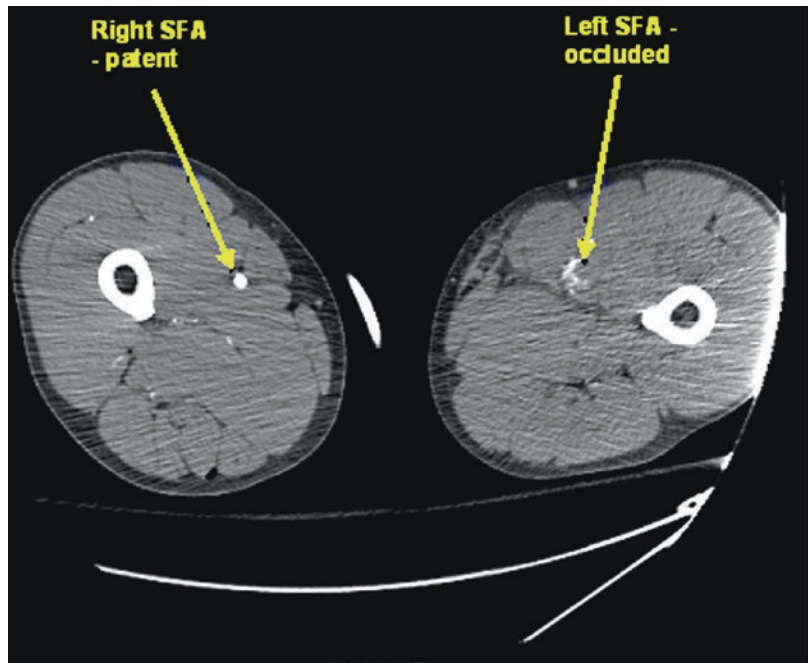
Axial CT demonstrates occlusion of the left SFA in the more distal extremity. Note the normal, patent right SFA
